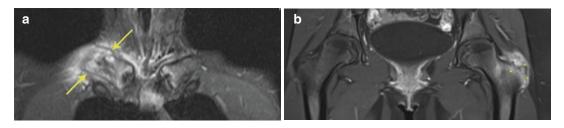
T2-weighted MRI findings of (a) expanded, irregular clavicle (*arrows*) with BME in the same patient as Fig. 5.42 and (b) BME and enthesitis at the greater trochanter of a 14-year-old girl with CRMO
